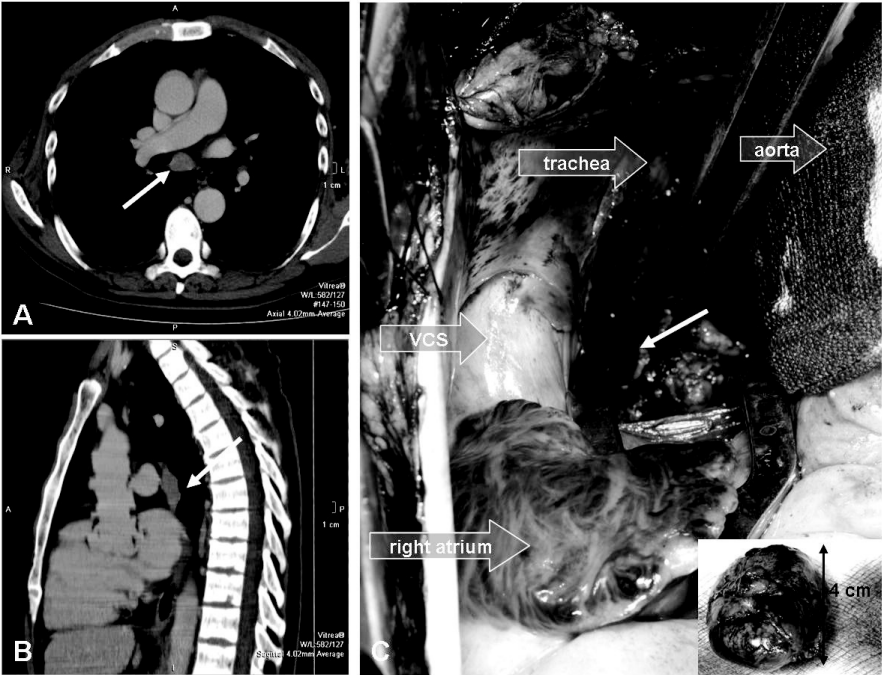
CT scan of the thorax demonstrating a large (4x3x2 cm) subcarinal mediastinal lymph noded metastasis (white arrow) (A+B), which was successfully excised using a transpericardial approach (C).
